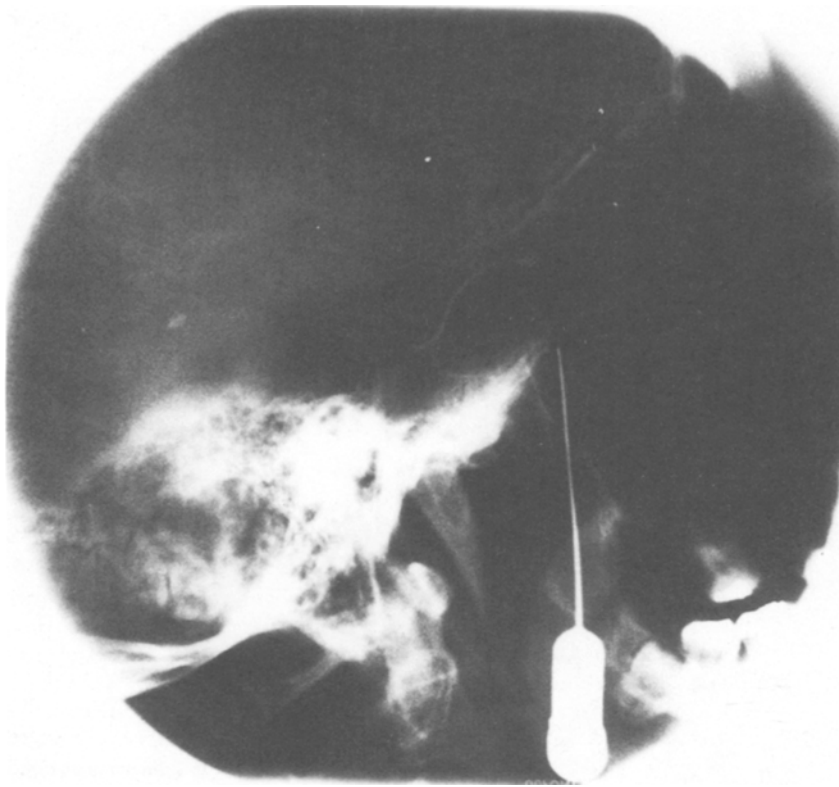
Roentgenogram of the skull, latero-lateral projection. The proper placement of the needle is confirmed by the position of the tip lying before and under the anterior wall of the sphenoidal sinus
